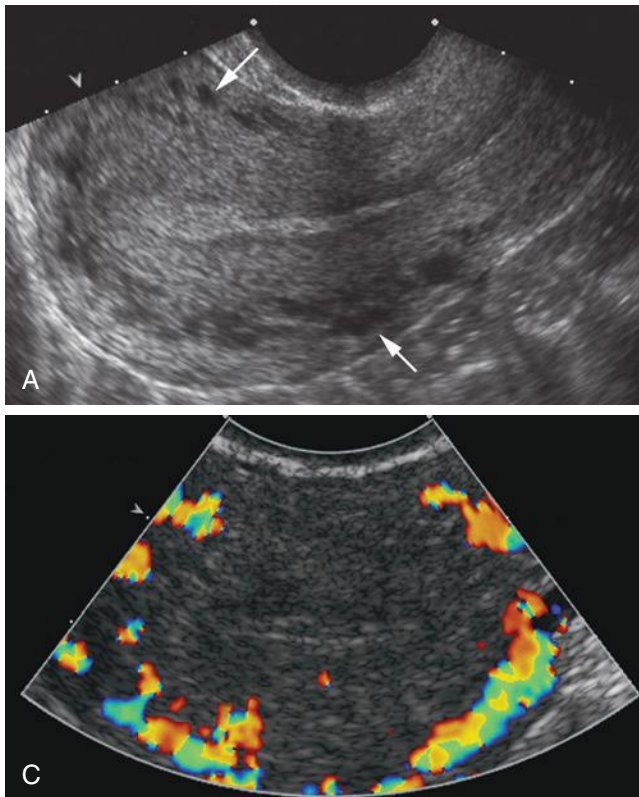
Transvaginal sagittal (A) and transverse (B) sonograms of the uterus demonstrating prominent anechoic round areas (*arrows*) between the outer third and inner myometrium. These are the arcuate vessels, which can mimic cystic changes. C, These cystic appearing spaces are confirmed to be arcuate vessels by applying color Doppler.
